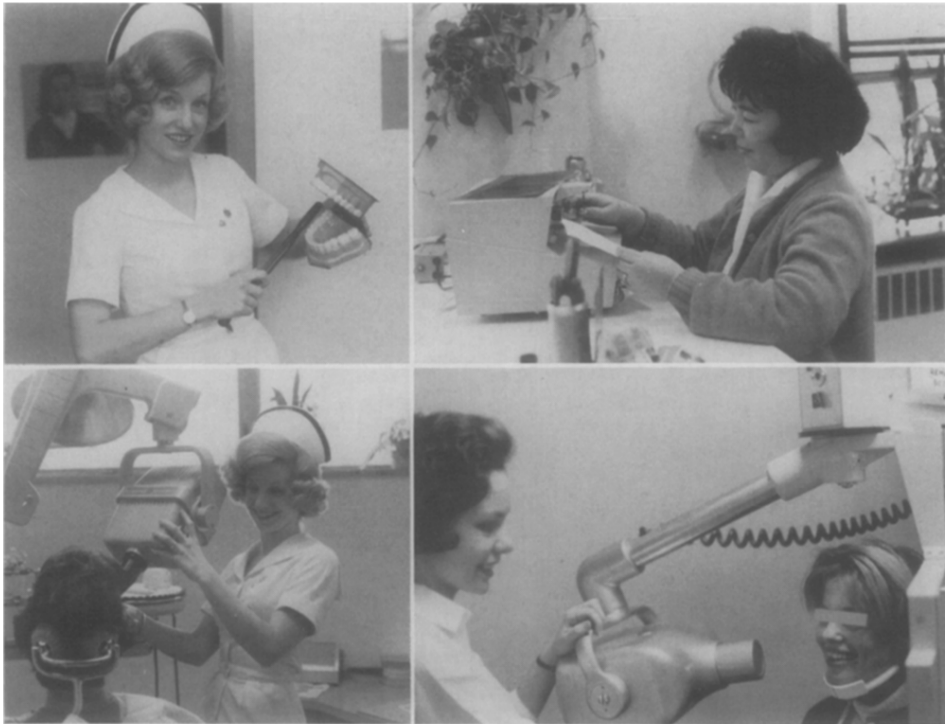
Additional duties that constitute a legitimate part of the routine of the hygienist and assistant include patient education, electric soldering, and the taking of intraoral and panoramic roentgenograms.
